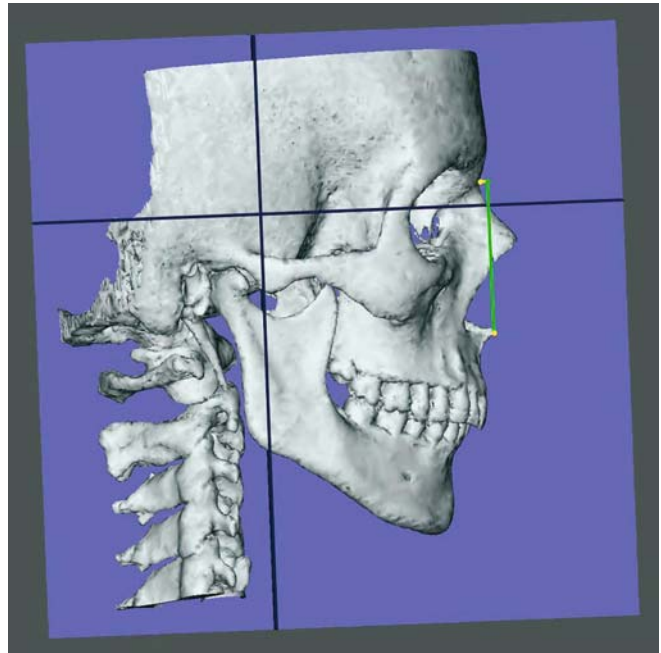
Anterior midfacial height, N-ANS (3-D CT, hard tissues, patient K.C.)
